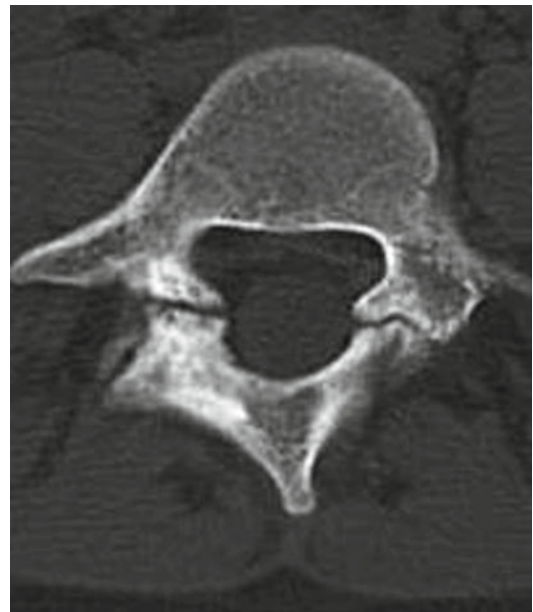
Fine cut CT scans are necessary in order to discern the spondylolytic defect, as seen in this image
